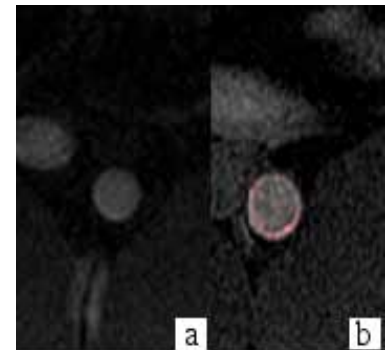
(Top right) Overlay of MR difference image and post-contrast image shows increased uptake of GdDTPA in vessel walls after ultrasound sonoporation (b) compared to no ultrasound exposure (a).
